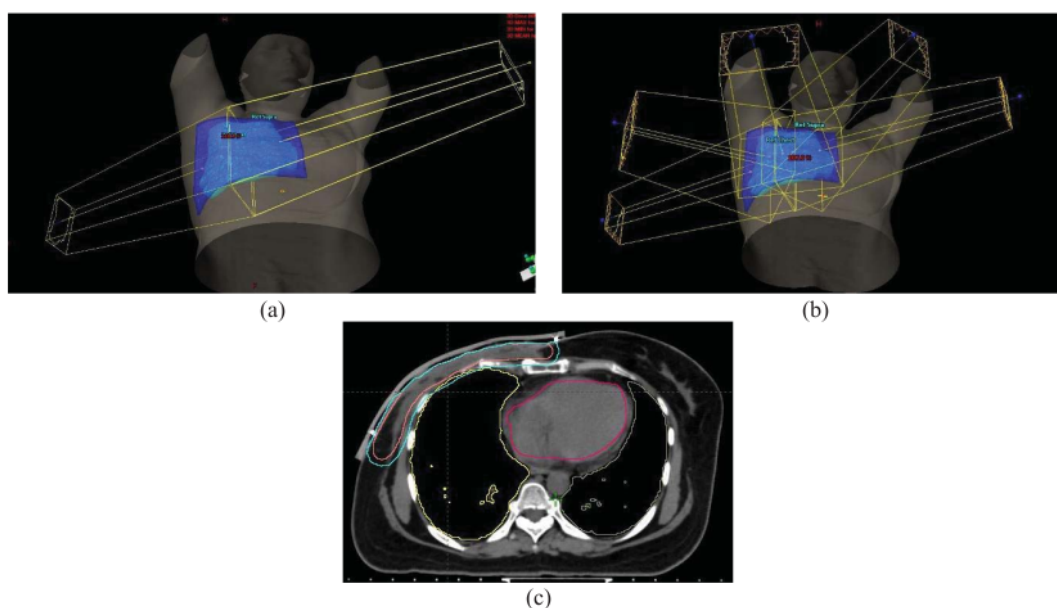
Chest wall radiotherapy planning (a) Tangential beam arrangement for 3DCRT, (b) Multibeam arrangement for IMRT. (c) CT image slice with delineation of chest wall's CTV (pink), PTV (blue), and organ at risk (lungs and heart)
